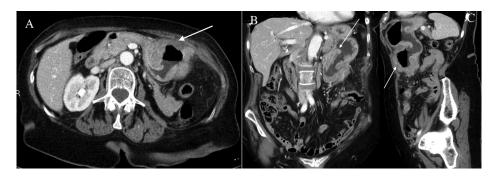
Initial contrast-enhanced CT image. (A) Axial view demonstrating diffuse thickening of the wall with a focal hypodense nonenhancing portion reflecting the necrotic mass (white arrow). (B) Coronal view demonstrating diffuse thickening of the wall with a focal hypodense nonenhancing portion reflecting the necrotic mass (white arrow). (C) Sagittal view demonstrating diffuse thickening of the wall with a focal hypodense nonenhancing portion reflecting the necrotic mass (white arrow).
